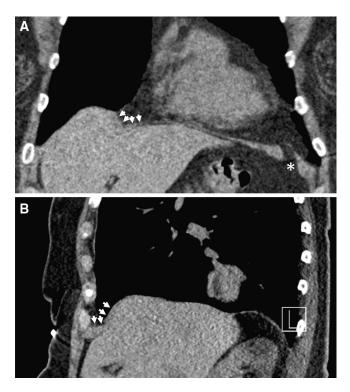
71-year-old woman with eventration of the right hemidiaphragm. A Coronal and B sagittal CT images demonstrate focal bulging of the anteromedial right hemidiaphragm over the liver. Close inspection reveals continuity of the diaphragm covering the eventration (*arrows*). Note also a slip in the left hemidiaphragm (*asterisk*).
